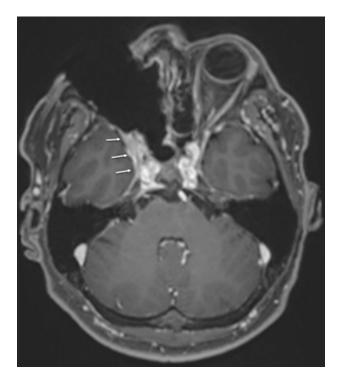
Follow-up MRI after orbital exenteration on the right side.
